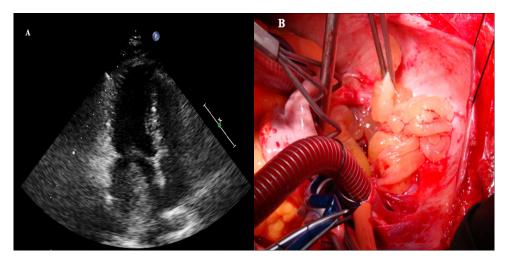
A, Transthoracic echocardiographic image of the patient showing a mobile giant mass in the left atrial cavity with obstruction at the mitral orifice. B, Intraoperative view presenting the emergent giant tumor mass just following the left atriotomy.
